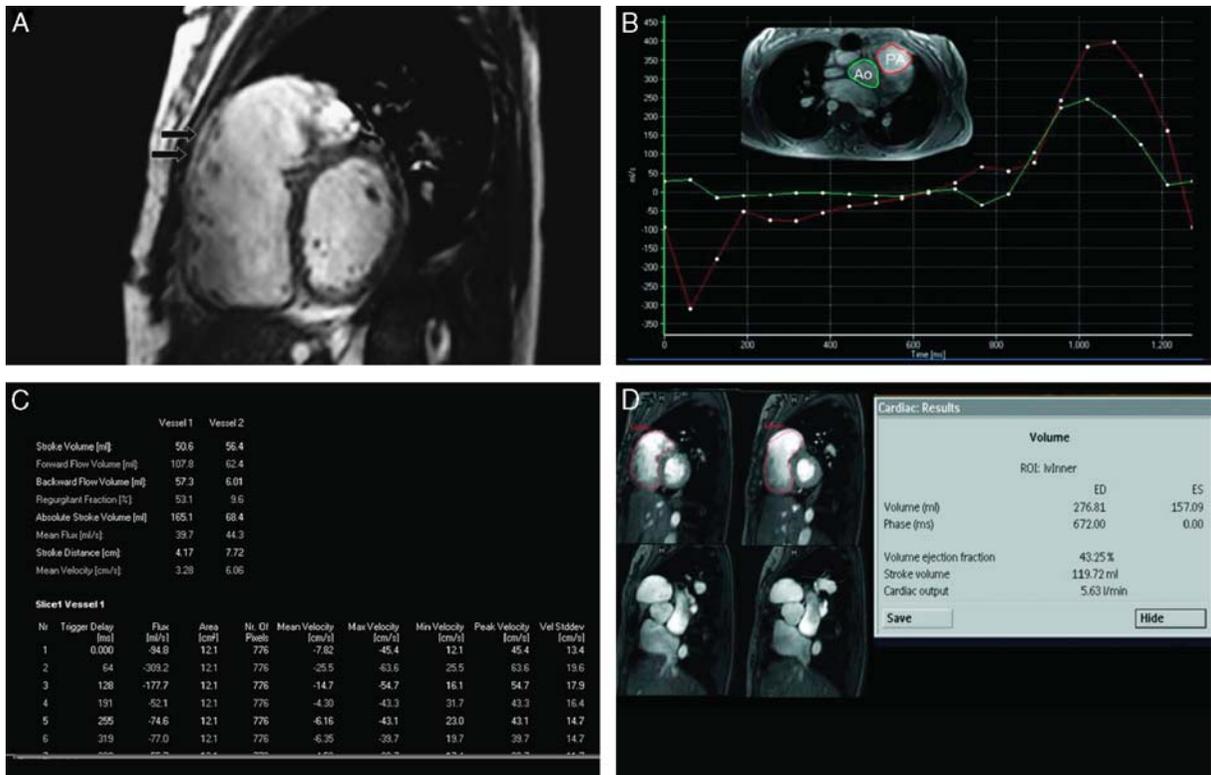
A 21-year-old woman after repair of tetralogy of Fallot in infancy presenting with dyspnea. MRI was performed to evaluate pulmonary regurgitation and right ventricular volumes before pulmonary valve replacement. A, Short-axis cine image shows post-operative aneurysmal dilatation of the right ventricular outflow tract (arrows). B and C, Quantitative flow measurements through the level of the pulmonary valve (vessel 1) and the aortic valve (vessel 2) show severe pulmonary insufficiency with a regurgitate fraction of 53%. D, Right ventricular volume measurements show an end-systolic volume of 157 mL, an end-diastolic volume of 277 mL, and a right ventricular ejection fraction of 43%. MRI indicates magnetic resonance imaging.
